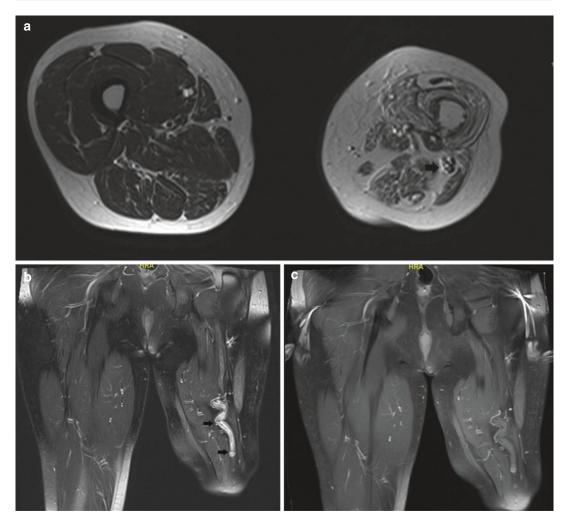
Amputation neuroma of the left sciatic nerve in 46-year-old male: (a) axial T2-weighted MR image; (b) coronal FS T2-weighted MR image. (c) Coronal FS T1-WI following administration of gadolinium contrast.
